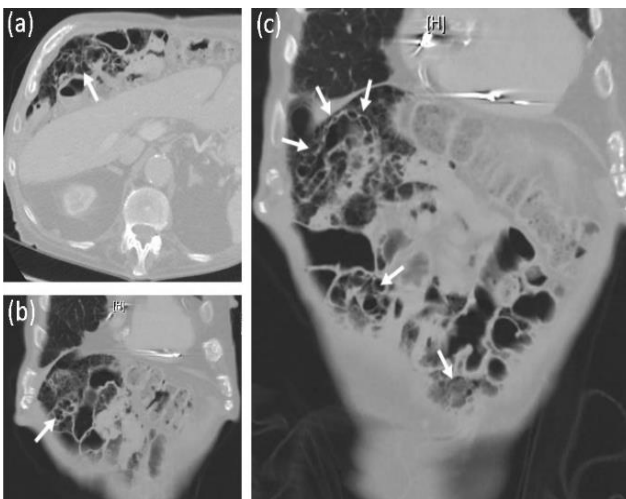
CT images of marked pneumatosis intestinalis (arrows) involving the large and small intestines in the right upper quadrant and mid abdomen. (a) transverse view. (b and c) coronal view.
